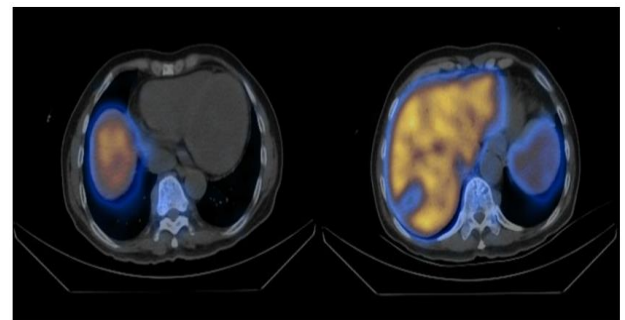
Fused images of the SPECT-CT scan. 12.3mCi of Tc-99 nanocolloid was injected intravenously. Segment VII mass shows reduced tracer uptake relative to liver parenchyma. There is also reduced uptake relative to vertebral bone marrow (right). Paravertebral soft tissue densities are seen along thoracic spine with associated minimal tracer uptake, representing foci of extramedullary haematopoiesis (left).
